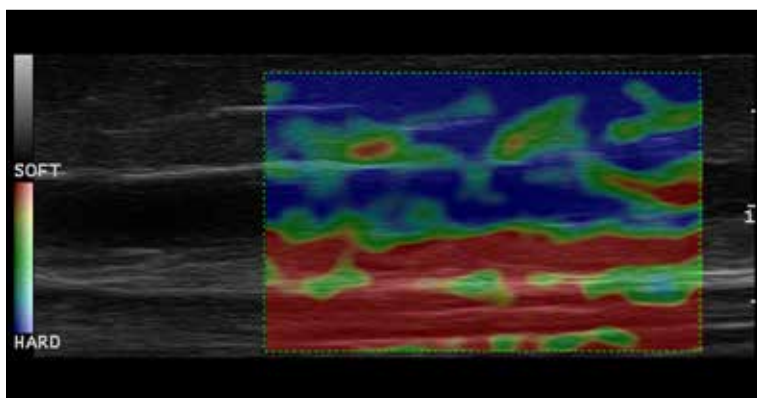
Follow-up ultrasound examination 14 days after the initial test. The thrombus with low-strain signal (blue) in US elastogram.
